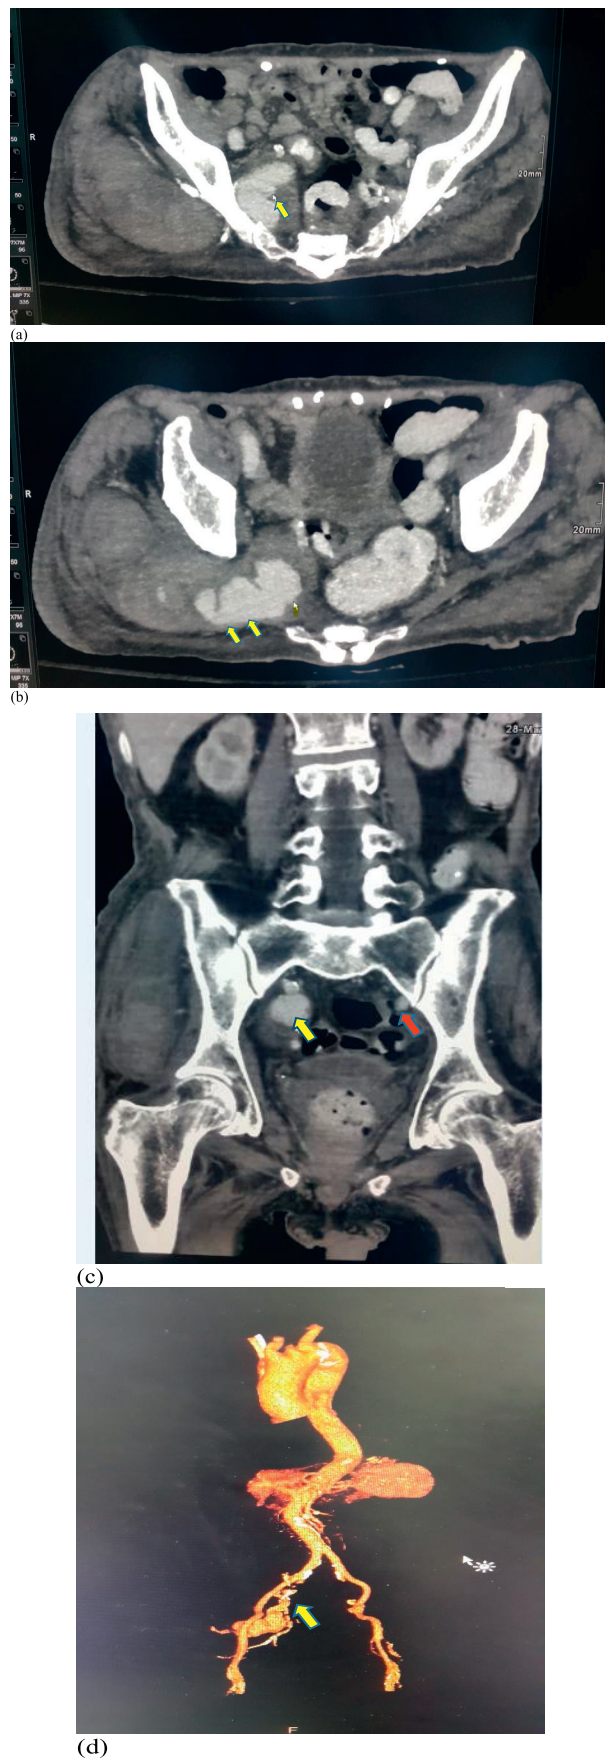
(a) CT with contrast showing right internal iliac artery leak (yellow arrow). (b) CT scan showing the leak extending into the right gluteal region (yellow arrows). (c) Sagittal view showing the right side internal iliac artery leak (yellow arrow) comparing with normal left side (red arrow). (d) 3D reconstruction of Figure 1a-c depicting the leak (yellow arrow).
